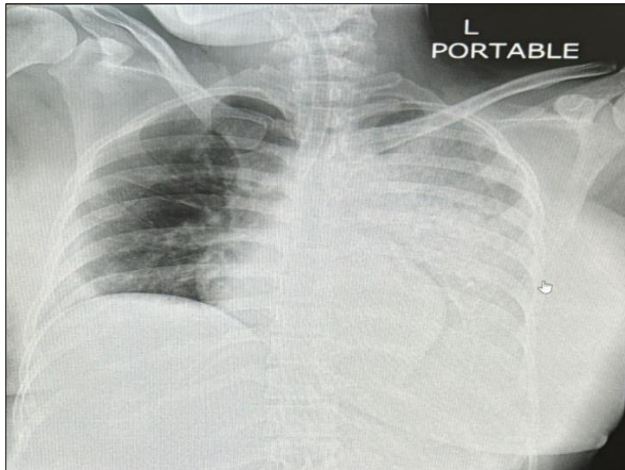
X-ray chest showing ground glass opacity in the left lung - mid and lower zones suggestive of non-cardiogenic pulmonary oedema.
